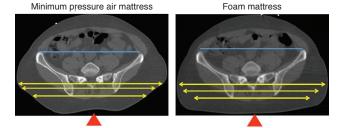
Low energy CT to determine ROI for the PET images. Tissue flattening on foam compared to minimum pressure mattress is here 3.4, 10.4, and 25.2% from top to down, respectively. The range is from 1 to 26 % depending on individual characteristics
